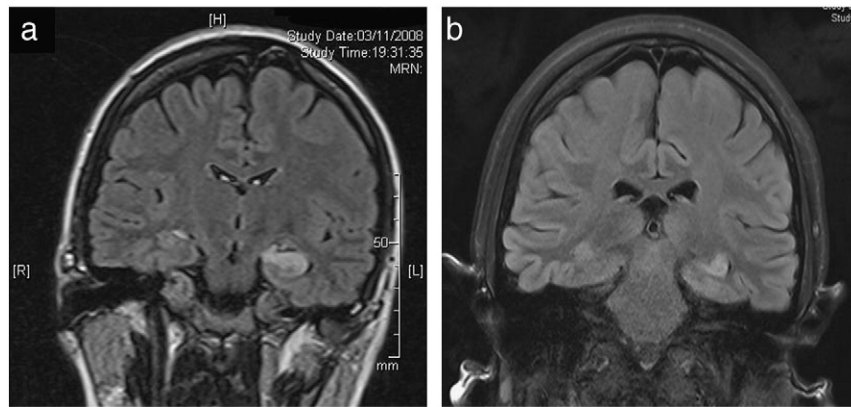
MRI scan showing hippocampal lesion. Brain MRI FLAIR sequence during acute presentation showing a hyperintense lesion in the region of the left hippocampus (a) which partially resolved in a subsequent study following clinical remission (b).
